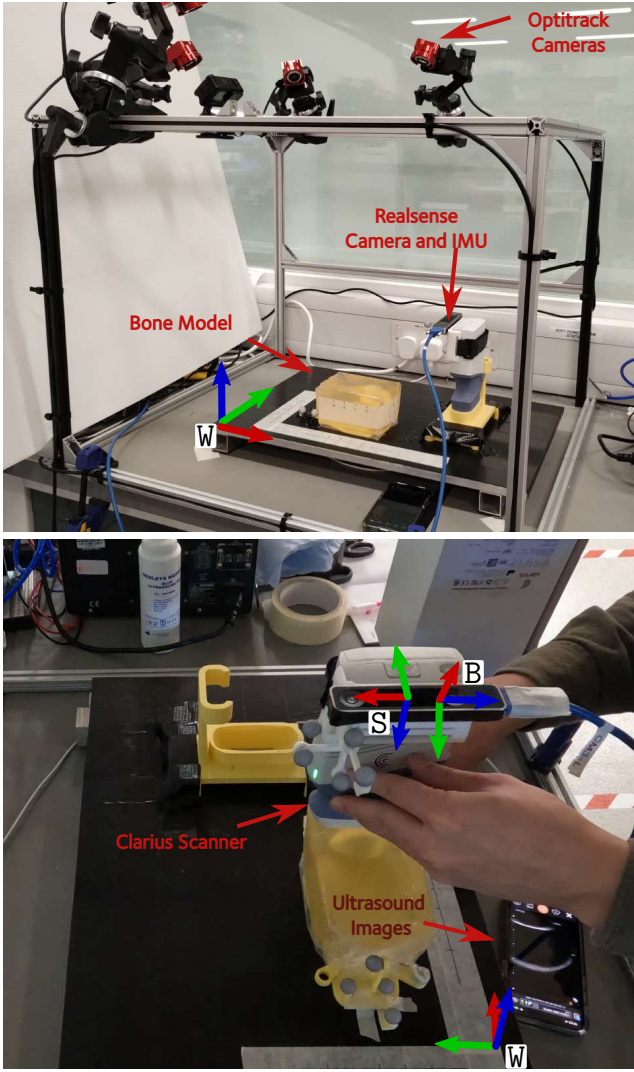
Experimental setup for collecting ultrasound dataset. A Realsense stereo camera is mounted on the Clarius ultrasound scanner and a mount holds the scanner in place. The human operator picks up the scanner and passes it over the bone model several times before returning it to the mount.
